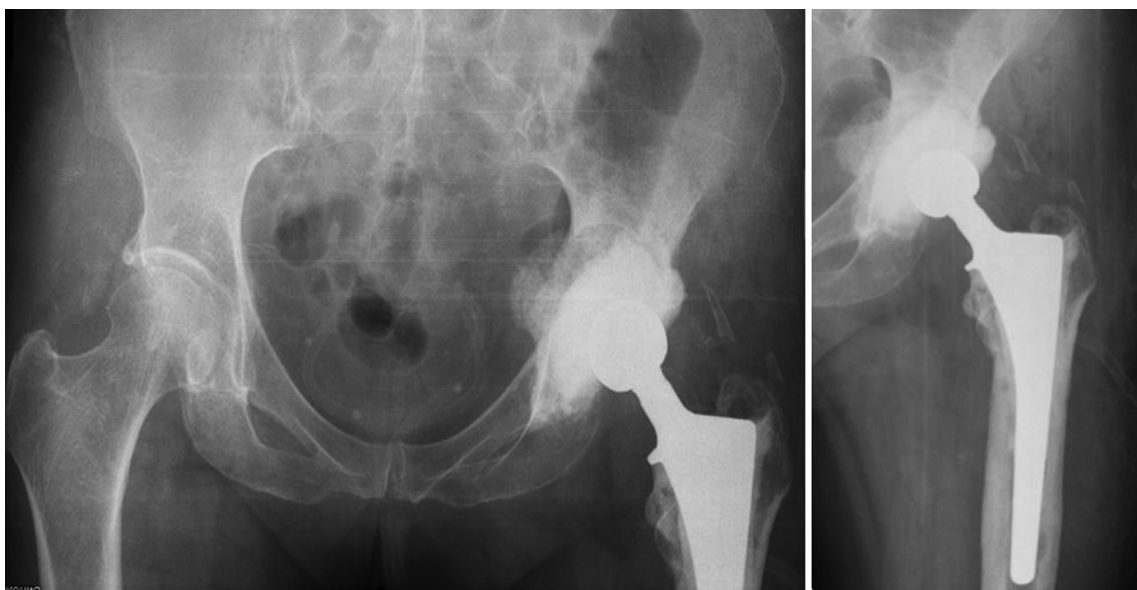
Radiographs of the pelvis and left hip joint after surgical treatment that comprised defect filling with allogene and installation of an articulating antibacterial spacer
